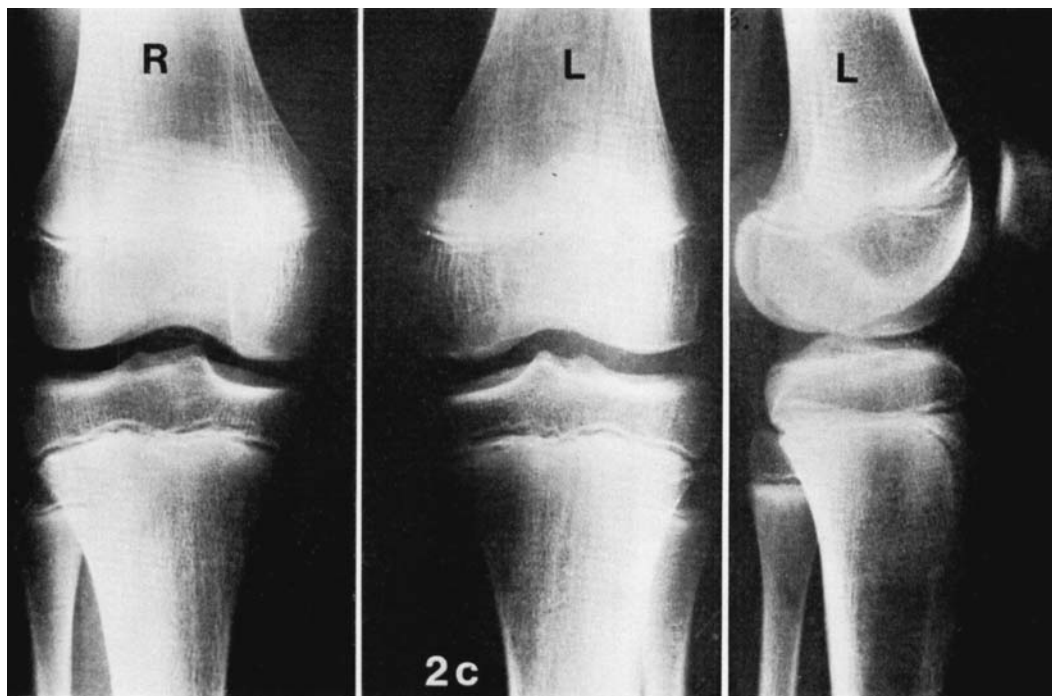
Case 2. a) X-rays of the knee joints of a boy at the age of 2 years showing separate ossification centres near the medial femoral epiphysis. b) Pre-operative X-rays at 3 years. c) Normal joints at 12.
